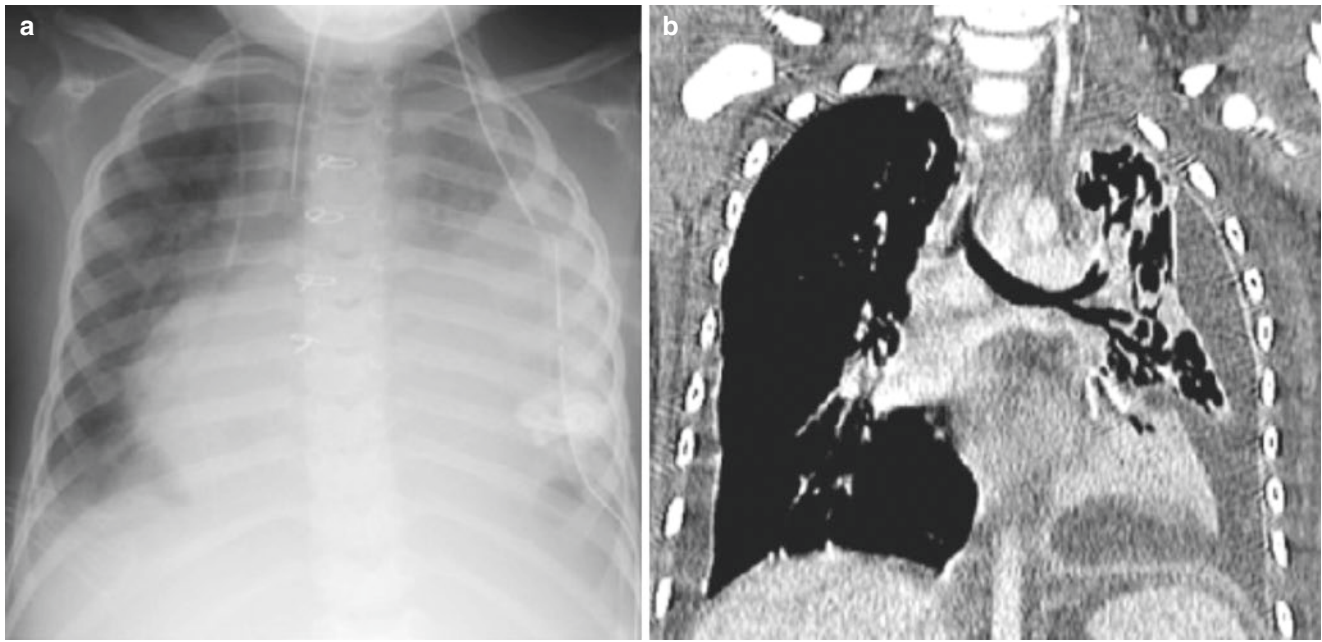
A 3-year-old girl with a history of repaired tetralogy of Fallot who presented with high fever and left chest pain. Multiple radiographs demonstrated a left lower lobe pneumonia and pleural effusion.
